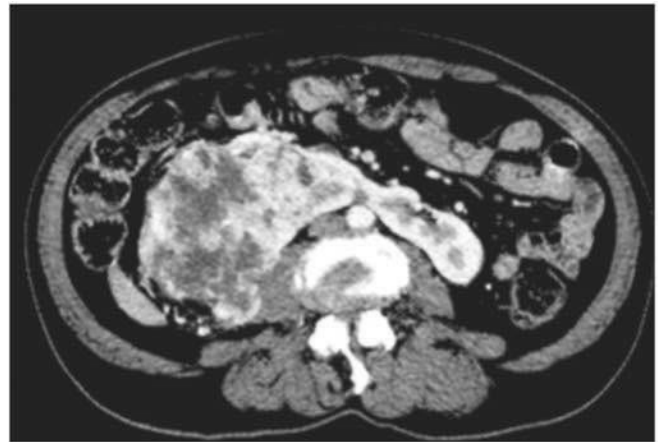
Cross section contrast enhanced CT scan of the abdomen, showing horseshoe kidney with right kidney mass anterior to the great vessels.
